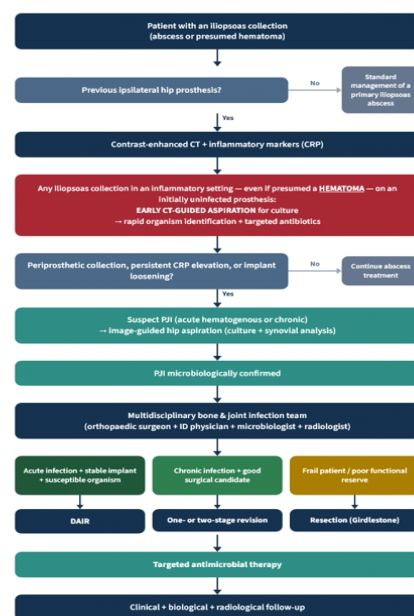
Proposed diagnostic and therapeutic algorithm. Note the early CT-guided aspiration step for any iliopsoas collection in an inflammatory setting on an initially uninfected prosthesis. DAIR: Debridement, antibiotics, and implant retention.
